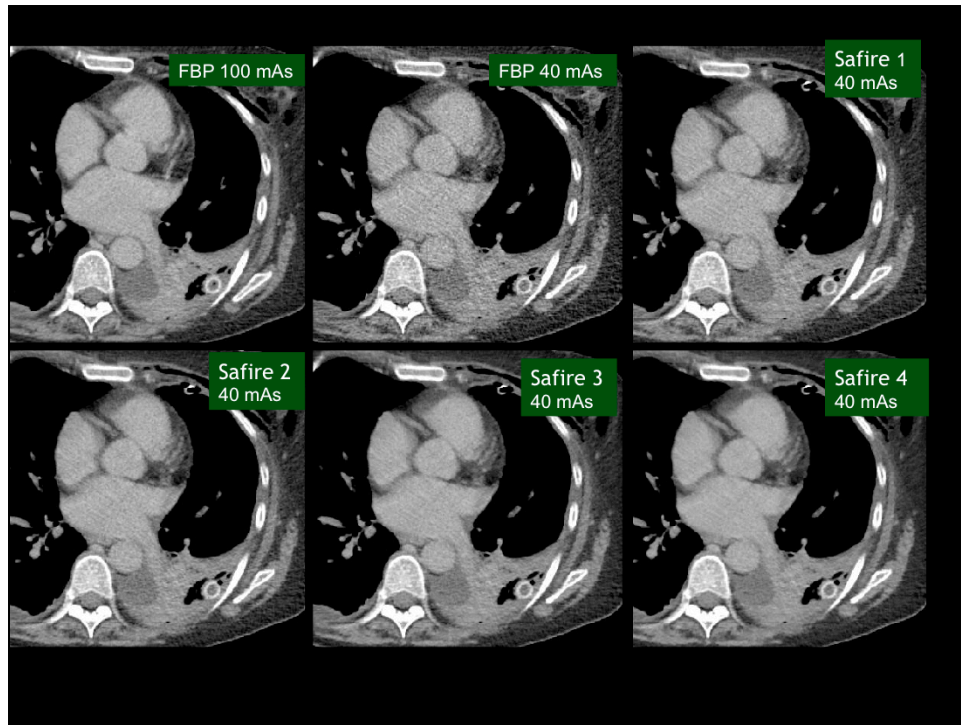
Transverse chest CT images showing loculated left pleural effusion, left lower lobe pneumonia and/or atelectasis, acquired at two tube current levels (100 mAs or 7 mGy & 40 mAs or 2.5 mGy). Low dose images (40 mAs) were reconstructed with iterative reconstruction techniques (Sinogram Affirmed Iterative Reconstruction, SAFIRE, Siemens Healthcare) at various settings (settings 1-4). Higher settings of the reconstruction technique results in lower image noise and allowing reduction of tube current.
